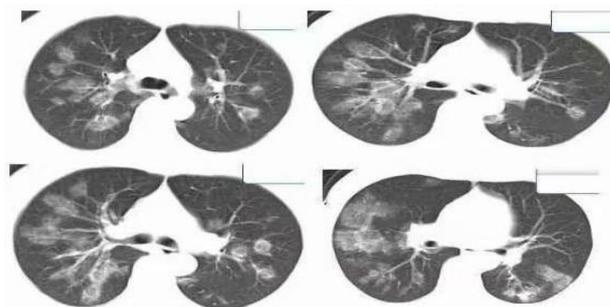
Chest CT showing multiple RHS in both lungs
